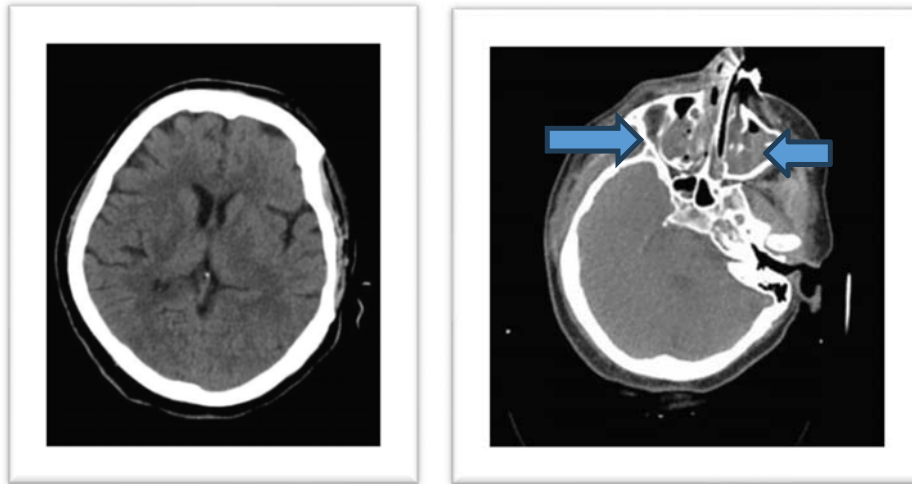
CT Head (plain) Normal (2b) CT Paranasal sinuses. Bilateral maxillary sinusitis with the possibility of fungal infection. (marked by the arrows) Erosion of the Lamina papyracea (medial wall of the orbit) on the right side.
